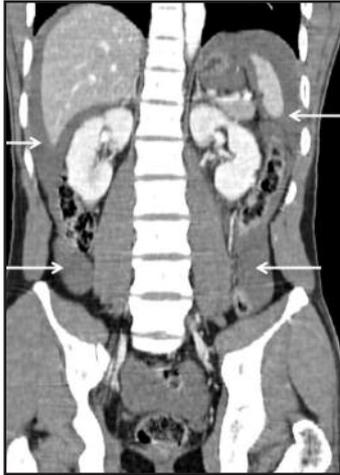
Coronal CT abdomen. Massive haemoperitoneum from bowel and mesenteric injuries. Free fluid collection in perihepatic, perisplenic and paracolic gutters (arrows) in a patient with perforated jejunum, mesenteric tear and mesenteric contusions. Intraoperative blood loss was reported to be 1200mL. Small bowel resection with end-to-end anastomosis was done and this patient recovered well.
